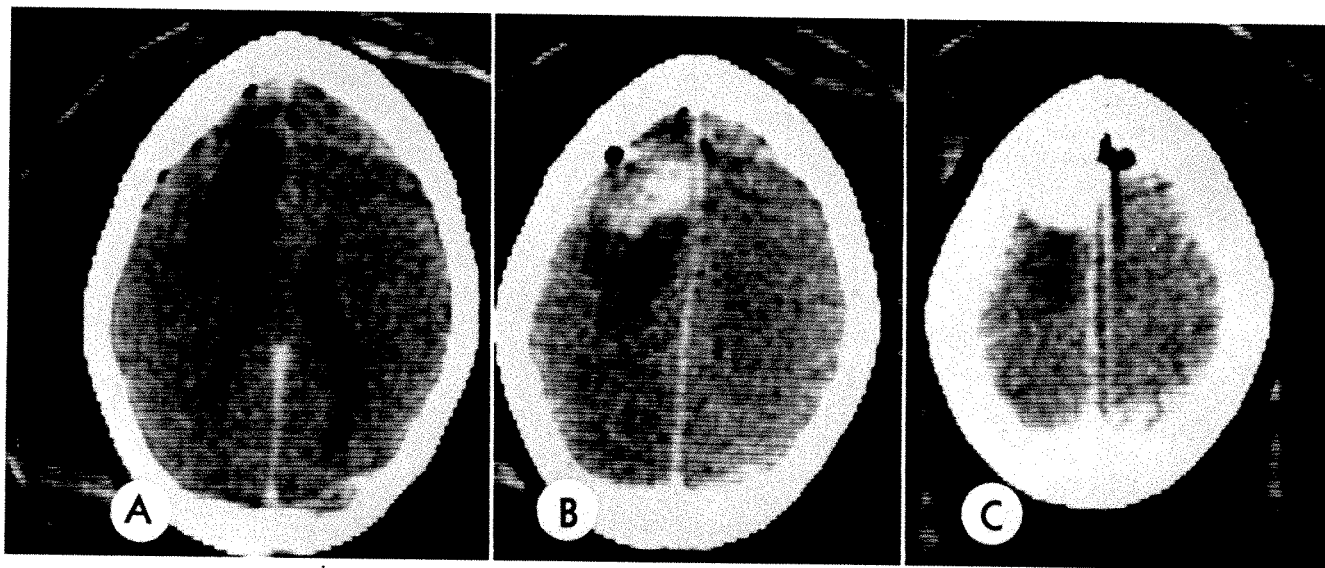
CT with contrast, contiguous slices. *A*, Large area of reduced tissue density in left posterior frontal region. *B* and *C*, Slices superior to 3A. Lobulated dense left frontal meningioma anterior to zone of reduced tissue density.
